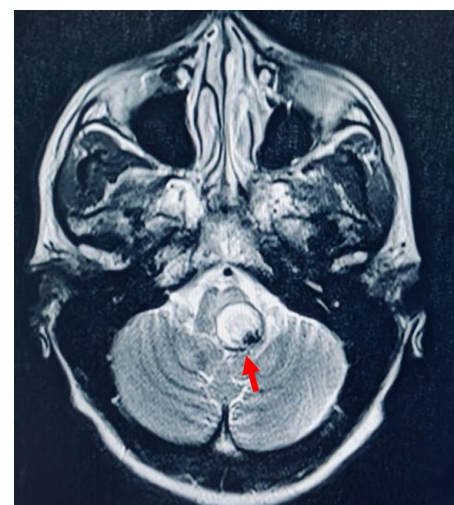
Axial section of T1-weighted brain MRI showing 2.5 cm left pontine hemorrhagic cavernoma (red arrow).
